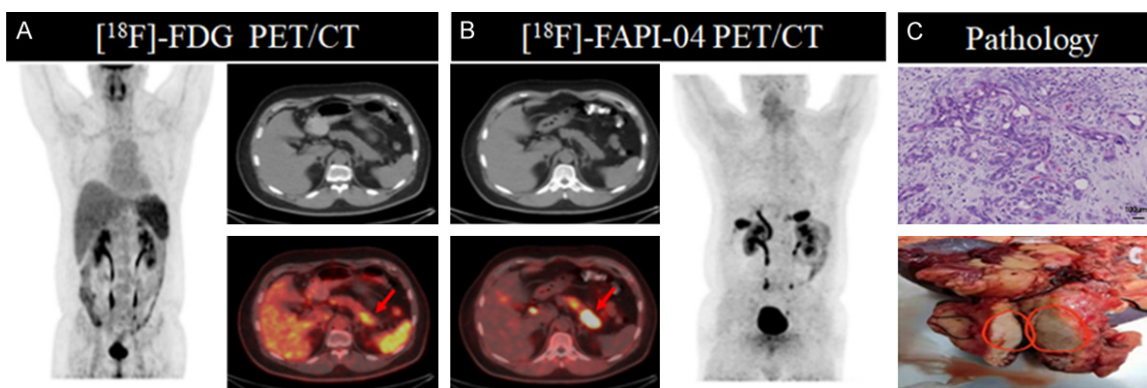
Results of pancreatic cancer examination. A 43-year-old man had abdominal pain for 2 months and elevated CA199 level. He self-reported that pancreatic MRI revealed a suspected malignant tumor occupying the pancreatic tail. Further evaluation with [¹⁸F]-FDG PET/CT and [¹⁸F]-FAPI-04 PET/CT was performed before treatment. A. [¹⁸F]-FDG PET/CT images demonstrated pancreatic tail occupancy with SUVmax: 6.5. B. [¹⁸F]-FAPI-04 PET/CT images displayed pancreas tail occupancy with SUVmax: 22.7. In addition, the pancreatic body inflammation was very clear. C. Surgical pathology indicated a moderately differentiated ductal adenocarcinoma of the pancreas, Scale bar, 100 µm.
